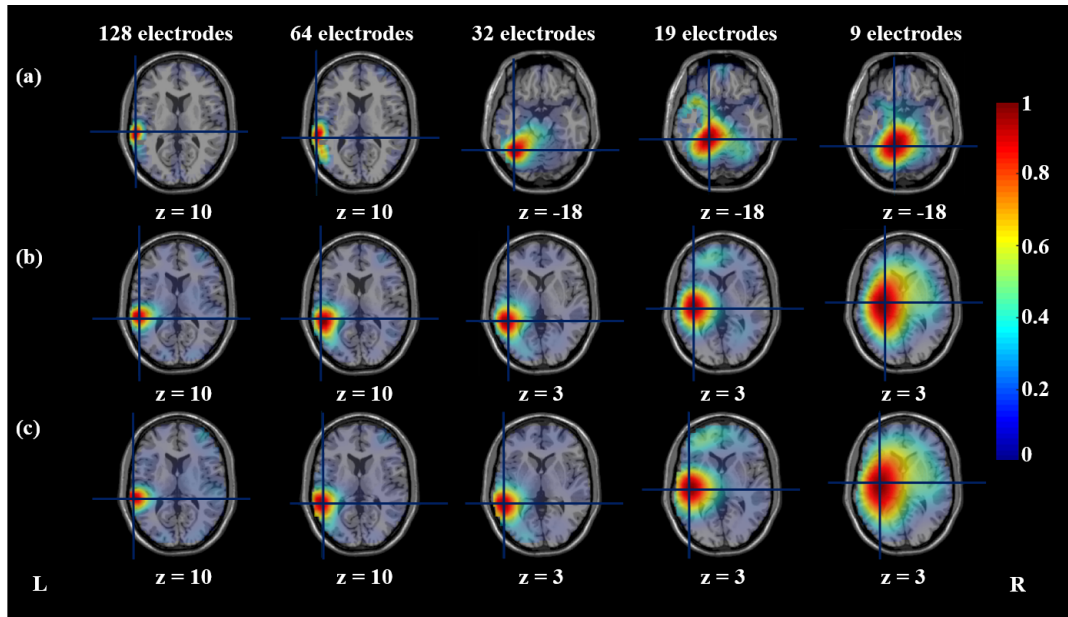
EEG source imaging results via STKF of an averaged spike selected from the EEG dataset, which was generated from the left lateral temporal source with  $5 \text{ cm}^2$  source area. STKF results using a gray-matter 3D grid and the classical Laplacian matrix are depicted in (a). Results using a full-brain 3D grid and the classical Laplacian matrix are shown in (b). For the results shown in (c), a full-brain grid and the modified Laplacian matrix were used. The results from the 128-, 64-, 32-, 19-, and 9-electrode datasets are shown in columns 1-5 from the left, respectively. The results are visualized as axial MRI slices at each spike's peak, and the cursor is placed at the maximum of the estimated current density. Additionally the  $z$ -coordinates of the axial slices are shown in MNI coordinates. The source imaging results were visualized using the Fieldtrip software [OFMS11]
